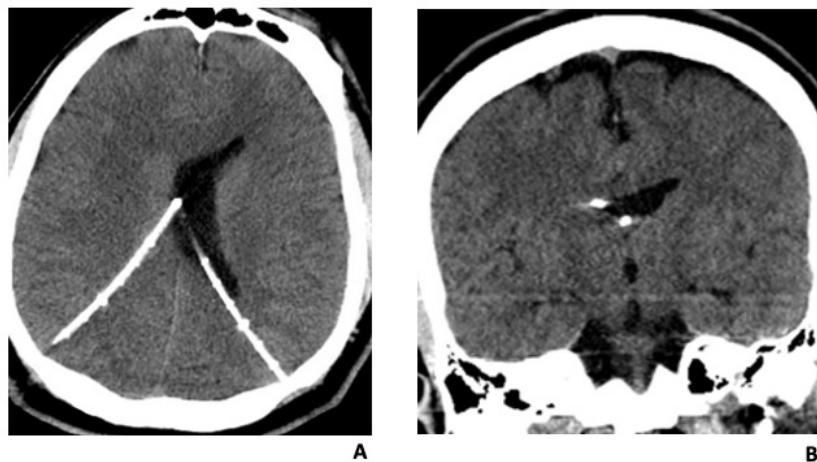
Non-contrast Head CT on admission axial (A) and Coronal (B) demonstrated grossly stable ventricular sizes with stable right parietal approach ventriculostomy catheter terminating along the right lateral ventricle and left posterior parietal approach ventriculostomy catheter crossing the left lateral ventricle and terminates at the vicinity of the septum pellucidum.
